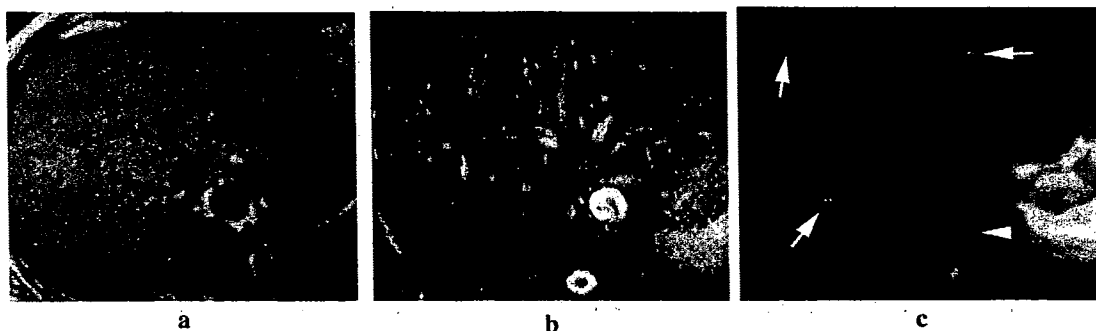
Lesion detection in the liver using free-breathing diffusion-weighted imaging (DWI). A 45-year-old woman with breast cancer. In this example, metastases were difficult to visualize on the (a) unenhanced axial T₁- and (b) T₂-weighted images. However, at DWI, (c) the high signal from intrahepatic vessels is suppressed by application of diffusion gradient on the $b=100 \text{ s/mm}^2$ image, enabling the metastases (arrows) to be clearly identified. Note also the incidental finding of a hemangioma within the vertebral body (arrowhead).
